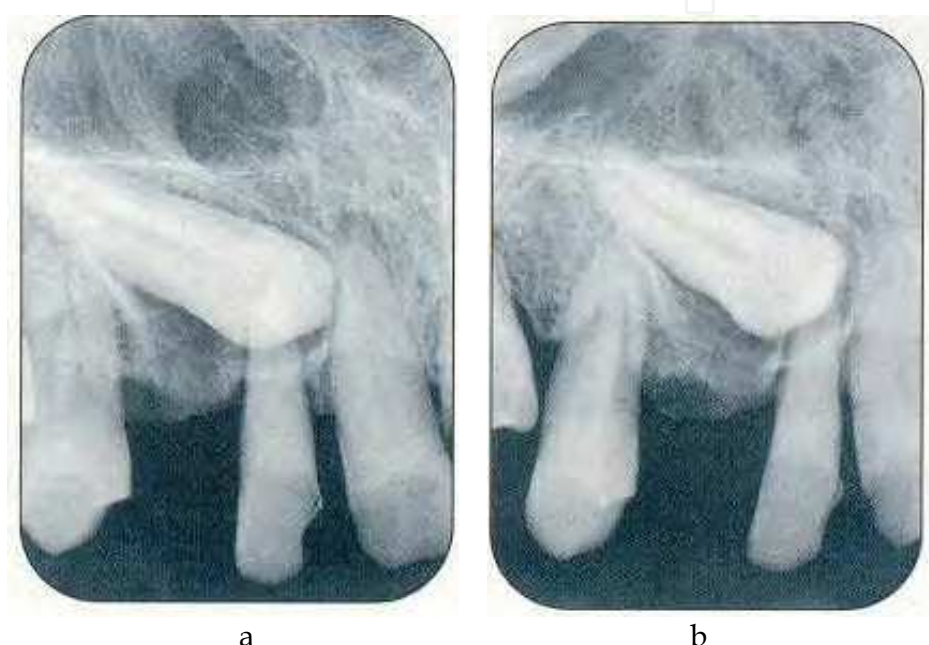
a) Periapical radiograph: with an orthocenter incidence. b) Periapical radiograph with a distocentric incidence. These two shots are needed to determine if the crown of the tooth is in position vestibular or buccal compared to others teeth.
